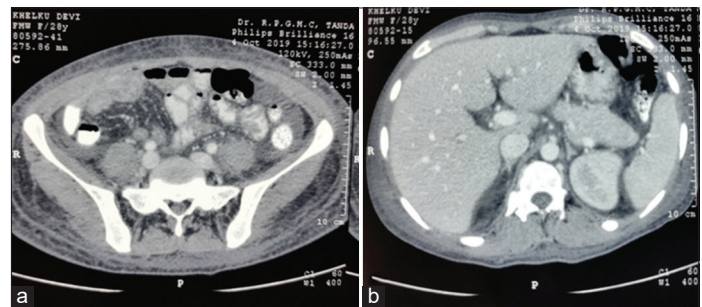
Contrast-enhanced computed tomography abdomen showing (a) mesenteric fat stranding along with round worm in the jejunal loops; (b) bulky body of the pancreas
